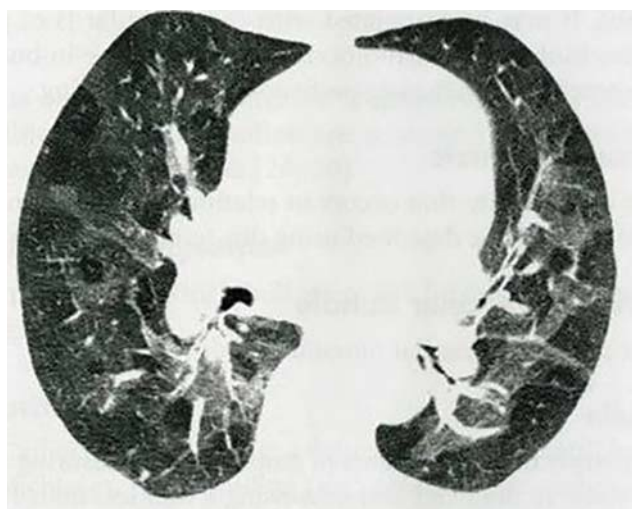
High-resolution CT shows ground-glass opacity
